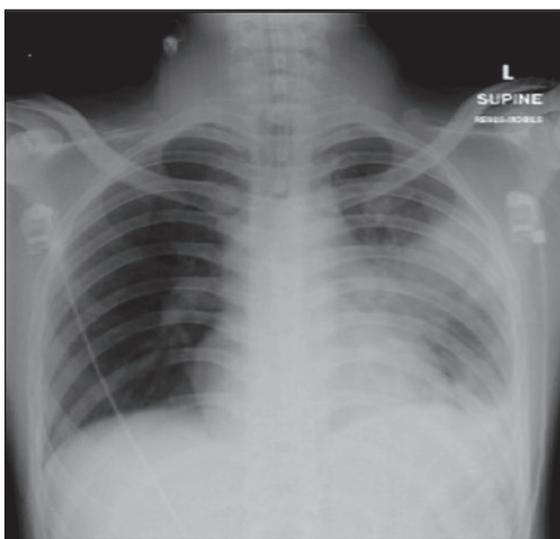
Chest radiograph of the patient in the case report revealing a wedge-shaped opacity in the left lower lobe which is a finding of pulmonary infarction (Hampton hump) at the left lung.
